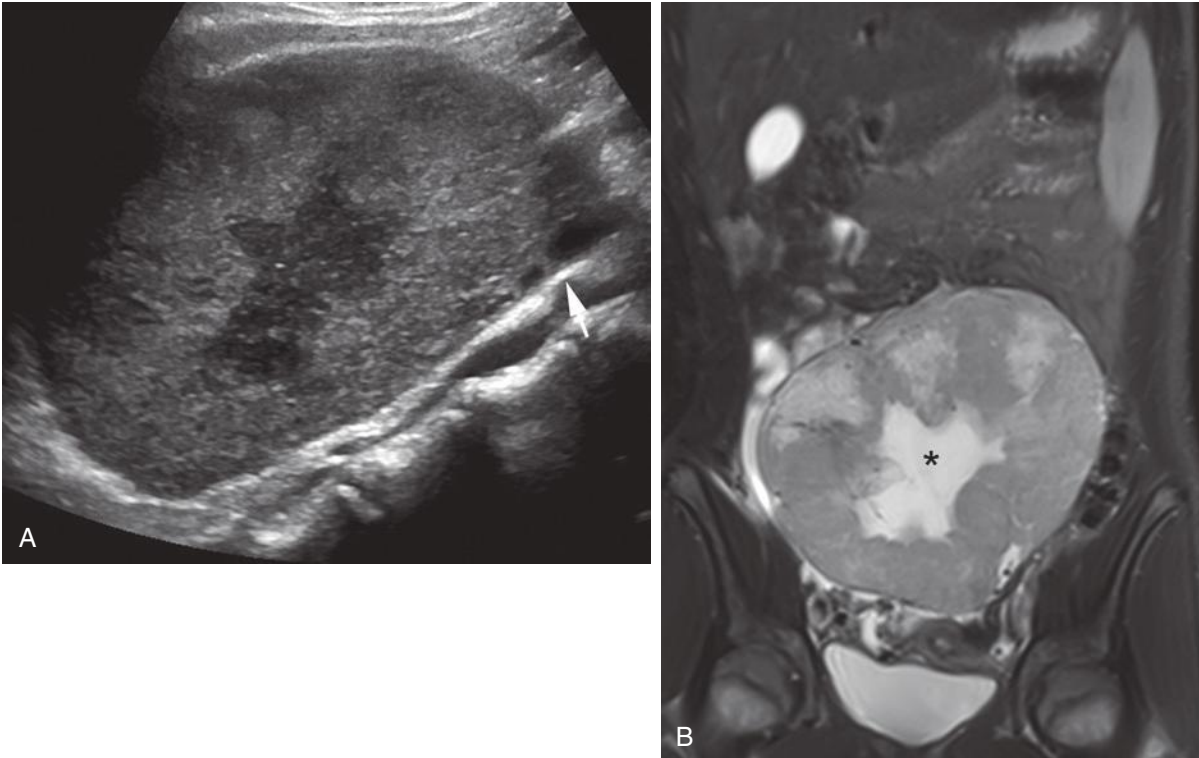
Ovarian dysgerminoma in an 11-year-old girl with abdominal pain, large abdominal mass, and an elevated serum hCG level. A, Sagittal ultrasound image demonstrates a large, predominantly solid lesion arising from the right ovary. A few normal-appearing ovarian follicles are noted adjacent to the lower pole of the mass (*arrow*). B, Coronal T2-weighted, fat-suppressed magnetic resonance image reveals a 14-cm diameter tumor with central necrosis (*asterisk*). Central geographic hypoechoic area likely represents central necrosis or edema. See Video 34-7.
